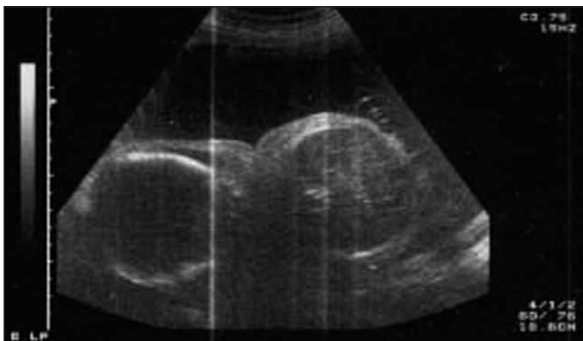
Ultrasonographic appearance.
